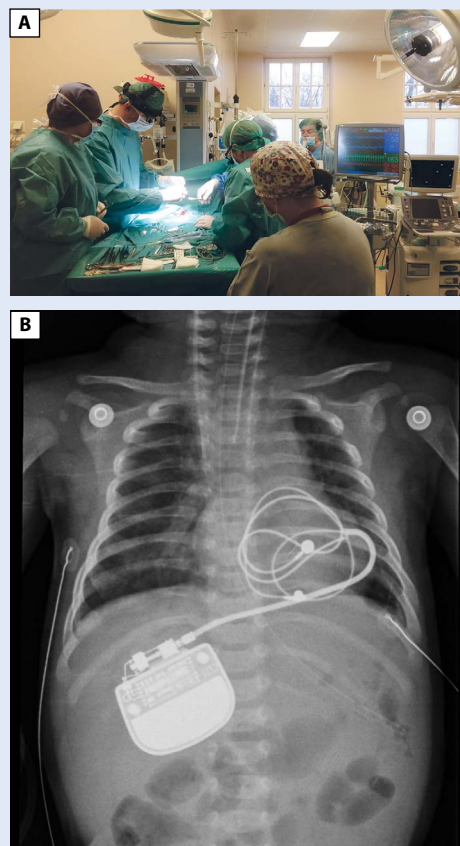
Pacemaker implantation in the delivery room in a newborn with congenital complete heart block (CCHB); A. Pediatric cardiac surgery team; B. Chest x-ray image of pacemaker implant
